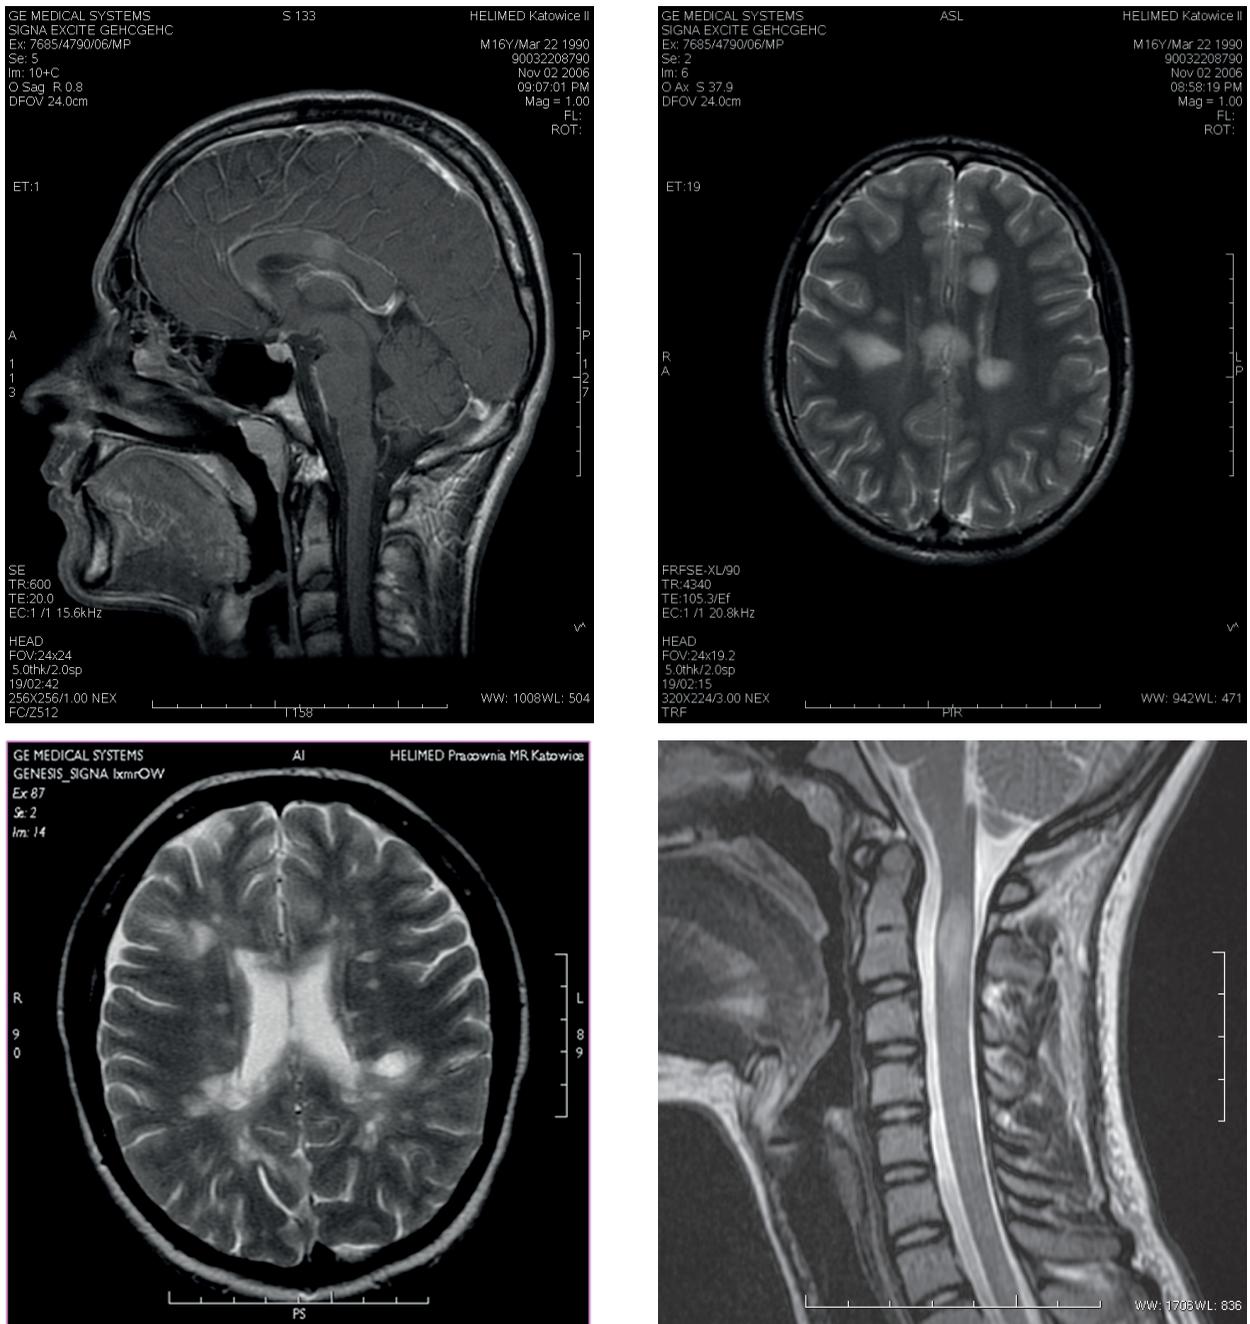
MRI features in MS
